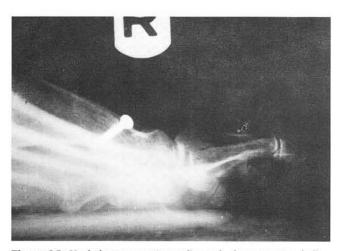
Healed postoperative radiograph demonstrating hallux malleus deformity.
